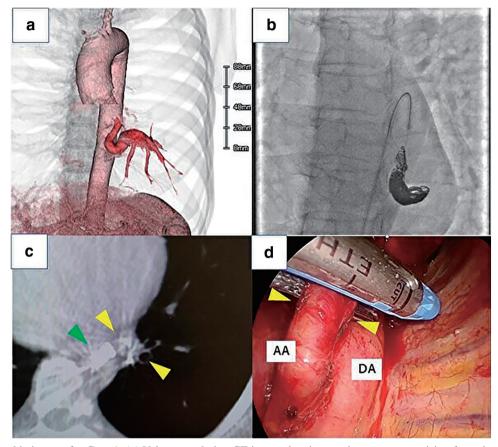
Radiographic images for Case 1. (a) Volume rendering CT image showing an aberrant artery arising from the descending aorta entering the left lower lung. (b) Experienced interventional radiologists performed coil embolization to occlude the blood flow of the aberrant artery on aortography. (c) Intraoperative CBCT showing the embolizing coils (green arrow) and metal clip marking (yellow arrows) to highlight the cut line of the aberrant artery and avoid cutting over the coils. (d) The aberrant artery was safely cut on the side peripheral to the embolizing coils using an automatic stapler referring to the metal clip markings (yellow arrows). CT: computed tomography; CBCT: cone-beam computed tomography; AA: aberrant artery; DA: descending aorta
